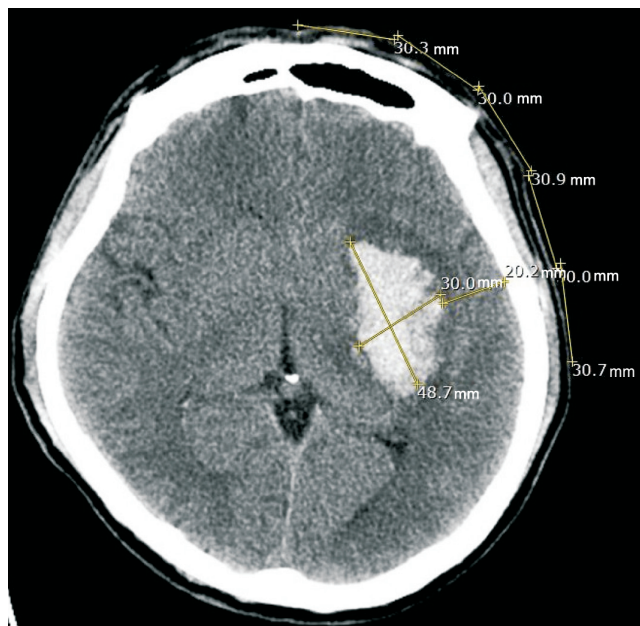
Pre-operative computed tomogram of the male patient aged 49. The intracerebral hematoma size and the distance to the cerebral cortex were measured, hematoma projection on the calvarium was calculated
